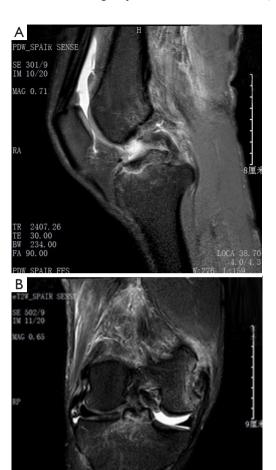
Sagittal and coronal MRI showing the avulsion fractures of the ACL from the tibial insertion and of the PCL from the femoral attachment. MRI, magnetic resonance imaging; ACL, anterior cruciate ligament; PCL, posterior cruciate ligament.
